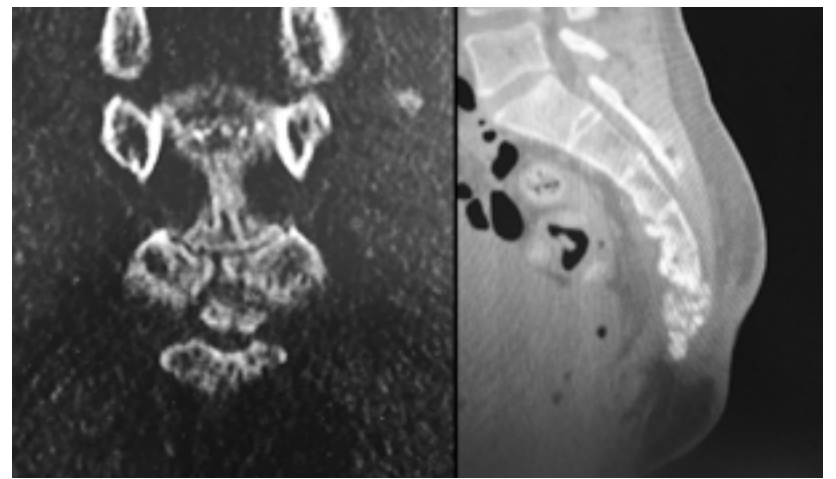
CT in sagittal and coronal sections in two different patients. Non-consolidated fracture of C1. Persistent bone fragmentation is noted on the right.
